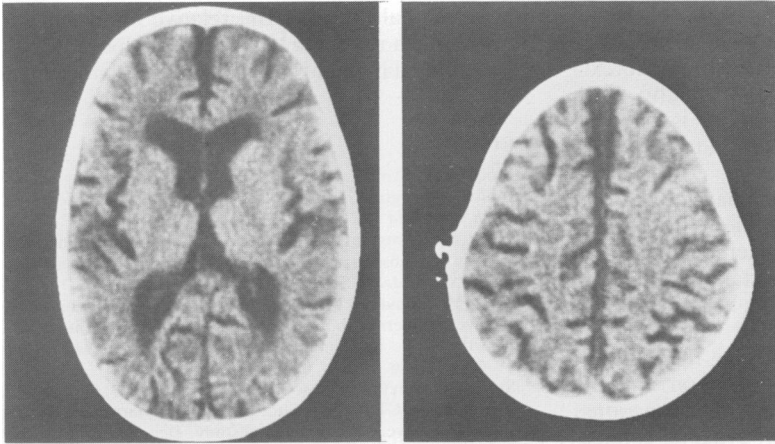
Computed tomograms of case 6, showing diffuse cerebral atrophy or shrinkage.*
